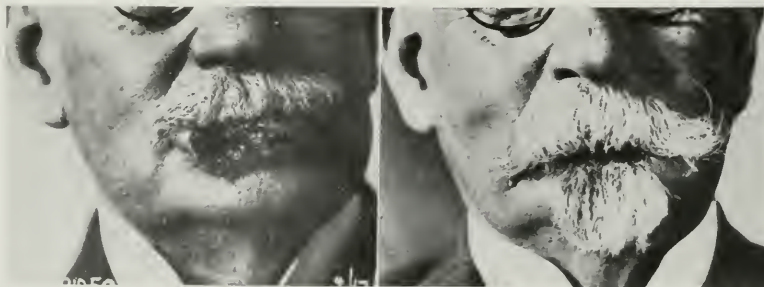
EPITHELIOMA INVOLVING THE ENTIRE LOWER LIP. SHOWING THE RESULT OF COMBINING ELECTROCOAGULATION WITH ROENTGEN RAY TREATMENT.
